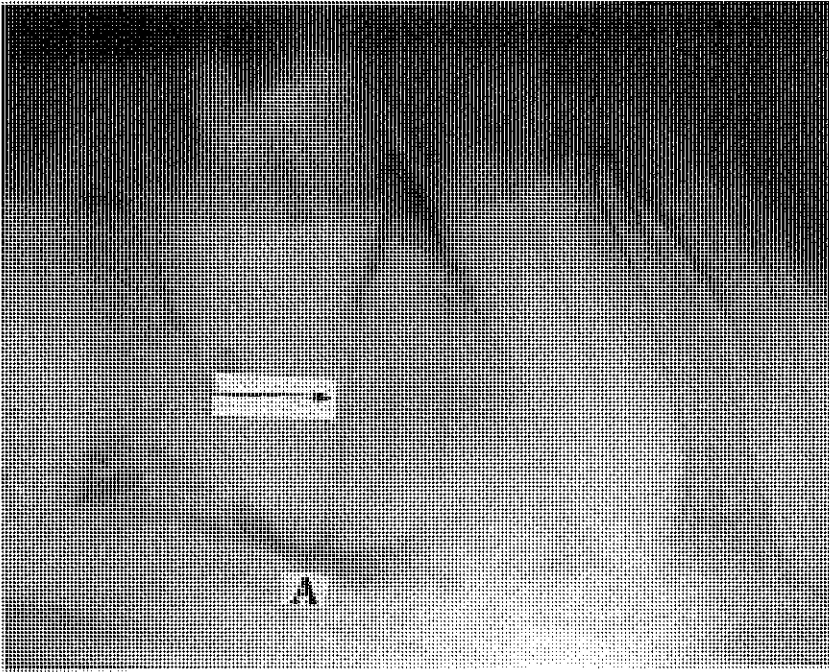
LACMHC 2002-L-116. Radiograph of mandible showing fracture through root (arrow) which terminates in apical abscess "A". Resulting inflammation produced osteomyelitis.
